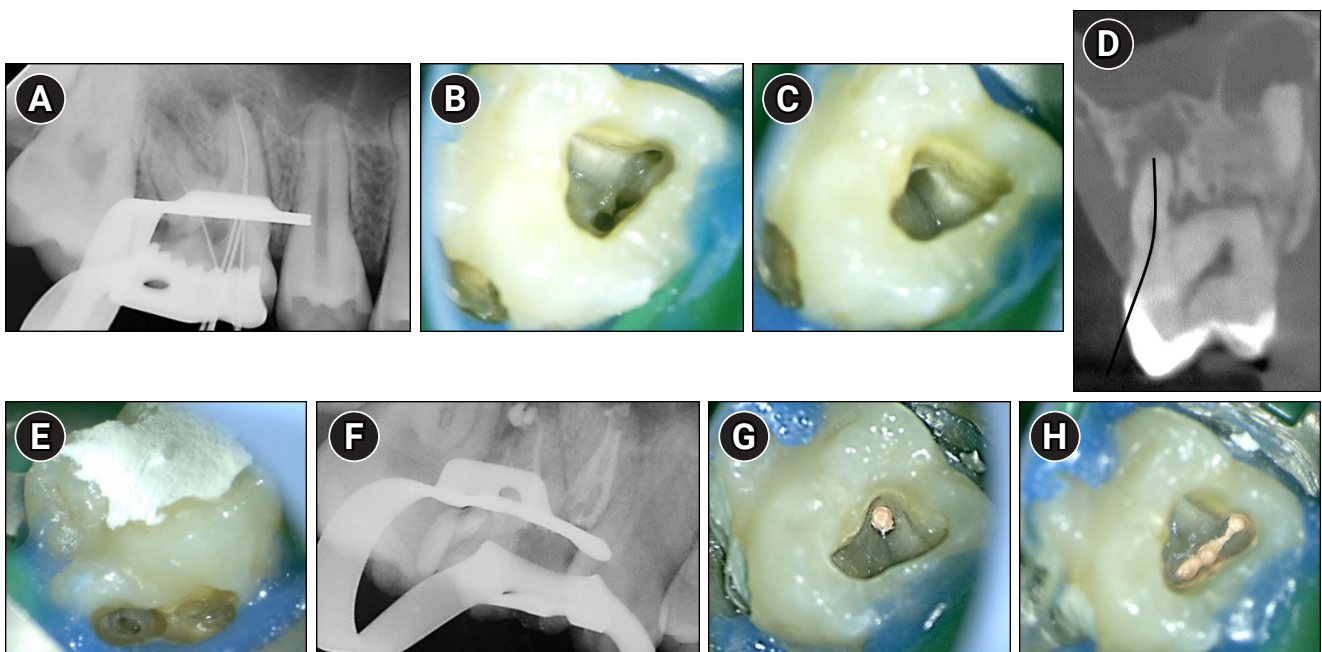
Endodontic management of maxillary right first molar (#16). (A) Working length radiograph taken after conventional access cavity preparation, showing four files in the buccal canals. (B, C) Clinical photographs of the pulp chamber floor showing three canal orifices in the mesiobuccal root and one in the distobuccal root. (D) Cone-beam computed tomography sagittal view showing the cervical access route chosen based on presumed palatal canal location. The black curved line indicates the presumed path for cervical access to the palatal canal. (E) Clinical image showing the perforation area after failed palatal canal identification. (F) Post-obturation radiograph confirming canal filling in three mesiobuccal and one distobuccal canal. (G) Clinical image showing obturation of the distobuccal canal with gutta-percha. (H) Clinical image showing well-condensed gutta-percha filling in the mesiobuccal canals.
